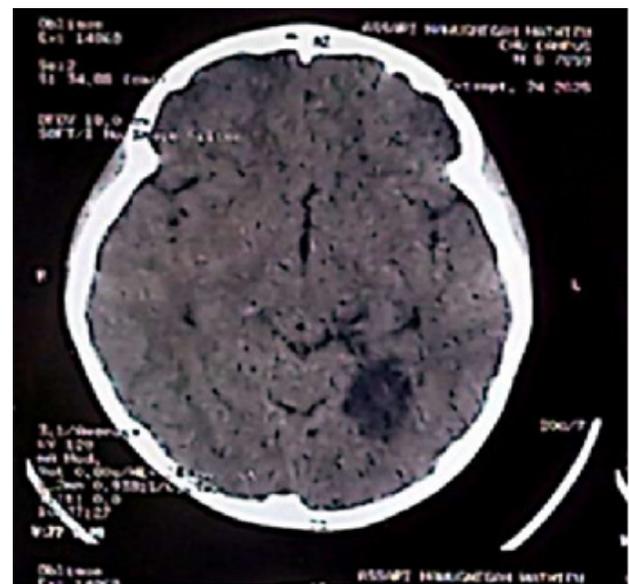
Brain CT scan demonstrating a left posterior cerebral infarction.
